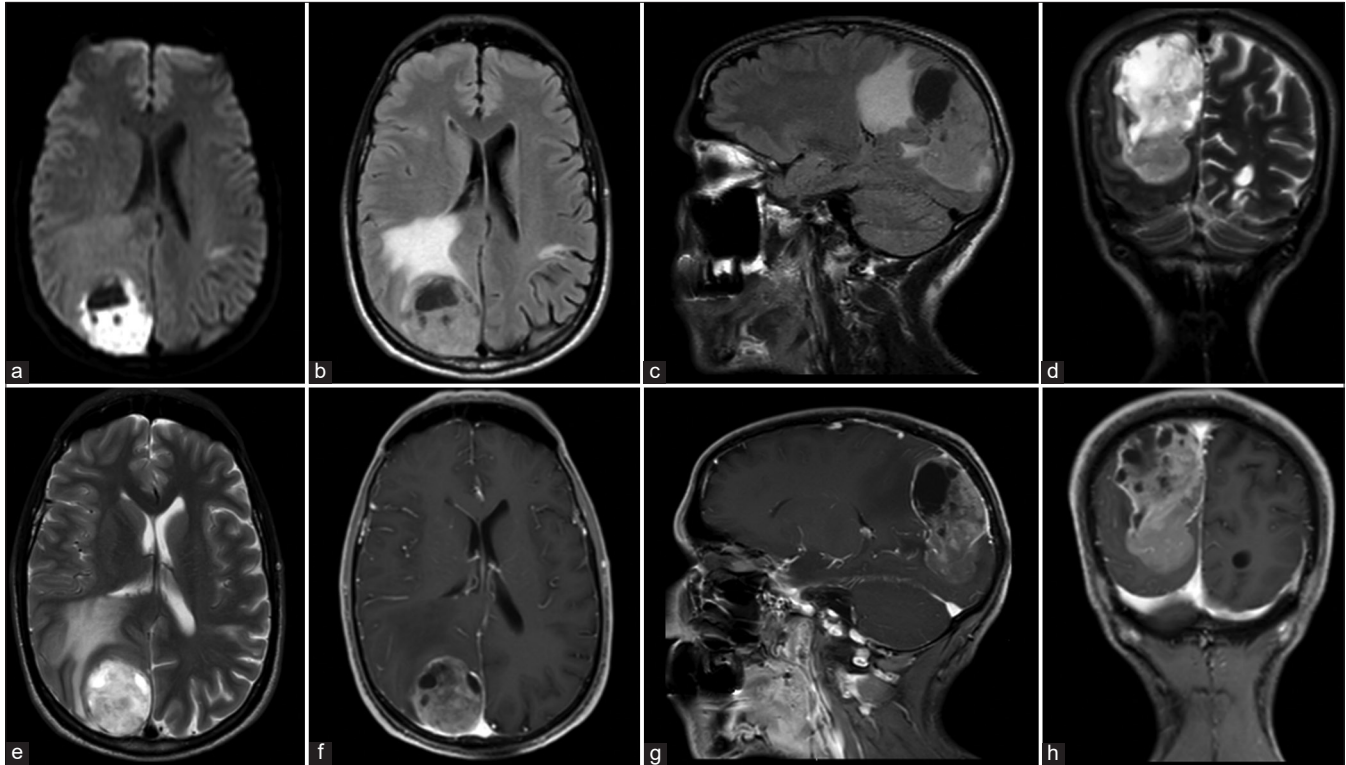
(A-H) Brain magnetic resonance imaging was done preoperatively. (a) axial diffusion-weighted image showing diffusion restriction in the solid part of the lesion. Fluid attenuated inversion recovery sequence images in (b) axial and (c) coronal planes, in addition to (d) coronal and (e) axial T2-weighted images showing a large solid and cystic intra-axial mass in the right parieto-occipital region with surrounding vasogenic edema. (f) axial, (g) sagittal, and (h) coronal gadolinium-enhanced T1-weighted image demonstrating an enhanced lesion and multiple loculations in the cystic component with a thick irregular enhancement of the wall.
